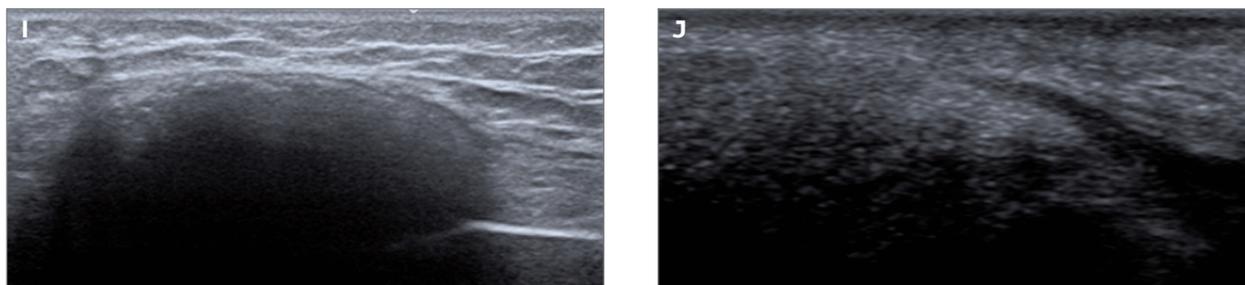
A 70-year old man, with chronic gout, mutilans form. a) Clinical photographs of the hands; b) hands radiograph, PA view: soft tissue nodular thickening with increased density (tophi), with calcifications. Mutilans form of hands deformations with large destructive osteolytic lesions in carpal and interphalangeal joints, with erosions resulting from intraosseous extension of tophi showing characteristic sclerotic edges. Bone loss; c) feet radiograph, AP view: soft tissue nodular thickening with increased density (tophi) with calcifications. Mutilans form of disease, with large destructive osteolytic lesions in MTP1 and IP joints of first toes (L>R) and MTP5 left, to less extent MTP 2-5 of the right foot. Moderate erosive lesions in Lisfranc joint of the right foot. Secondary osteoarthritis in tarsus. Bone loss; d) left elbow, lateral radiograph: topos/tophi with calcifications and bone loss. Notice the osteolytic lesions of the left olecranon and distal humerus; secondary osteoarthritis with joint space narrowing; e) right knee, lateral radiograph: increased radiodensity of periarticular soft tissues with calcifications, single calcifications seen at the level of metaphyses of the crura, popliteal fossae. Bone loss. Well defined erosions and cysts, mainly tibia, that results in secondary osteoarthritis; f-l) Different presentation of tophi at ultrasound: f) hyperechoic tophi in the wrist joint; g) hyperechoic tophus containing tiny calcifications; h) hyperechoic tophus containing MSU aggregates; i) a topos in the olecranon bursa with calcified surface, j) tiny calcifications in the suprapatellar recess; l) MSU aggregates within the patellar tendon.
